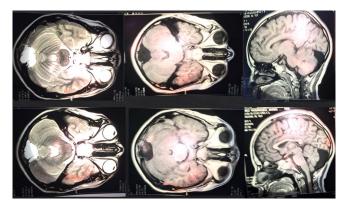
Head MRI showed the presence of mega cisterna magna.
